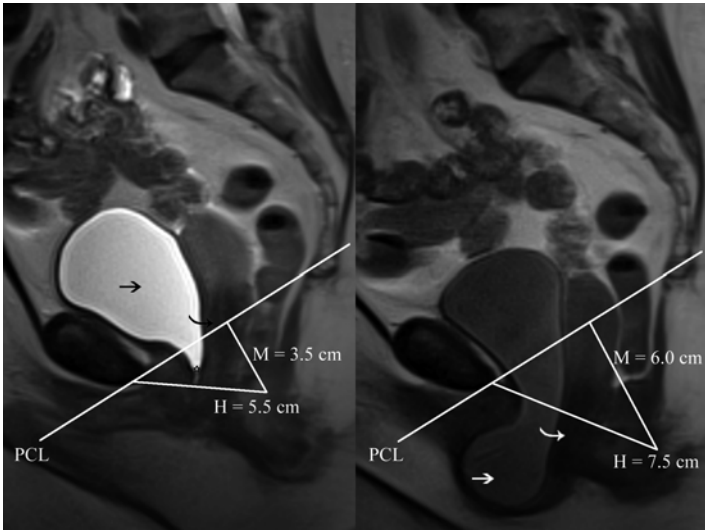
Sagittal T2-weighted MR images. The pubococcygeal line (PCL) extends from the pubic symphysis to the final coccygeal joint and roughly demarcates the pelvic floor. The H-line is measured from the pubic symphysis to the anorectal junction's posterior wall and should measure less than 5 cm; the M-line is the perpendicular drawn to connect the PCL and the H-line, and should measure less than 2 cm. All organs should remain above the PCL. As seen on the leftmost image, even at rest there is pelvic floor relaxation with pathologic H-line and M-line measurements. The bladder (*black arrow*) and uterus (*curved black arrow*) are mostly above the PCL, although there is mild prolapse of the urethra in particular (*asterisk*). With Valsalva, there is significant elongation of both H-line and M-line beyond their already pathologic baselines, as well as severe prolapse of the bladder (*white arrow*) and the uterus (*curved white arrow*), both dropping below the H-line.
